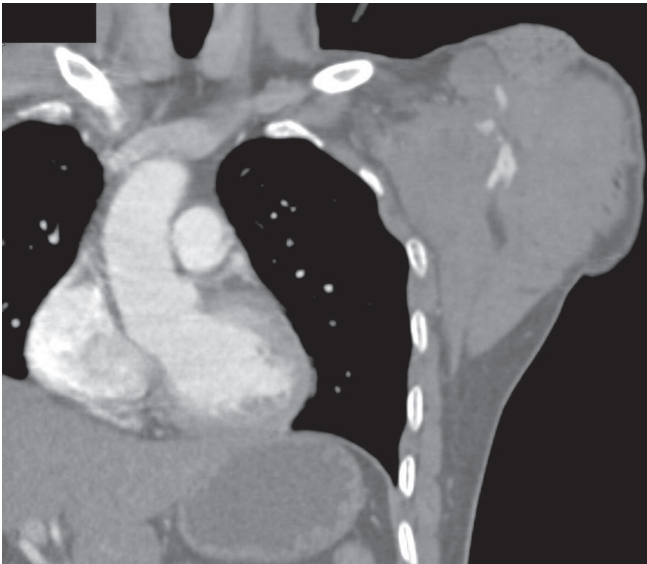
Coronal view of computed tomography angiography of a left axillary artery injury with active extravasation and surrounding hematoma.
